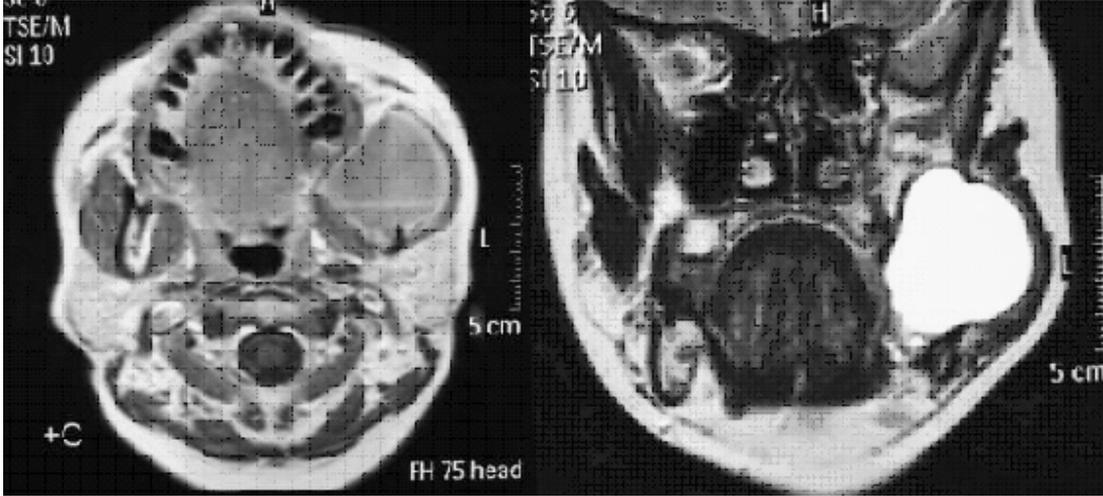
Axial enhanced T1 weighted MR imaging (a) and T2 weighted imaging (b) show cystic mass with fluid-fluid level and wall enhancement in buccal space. The neighboring masseter muscle was pushed and mandible was destructed by the cyst.
